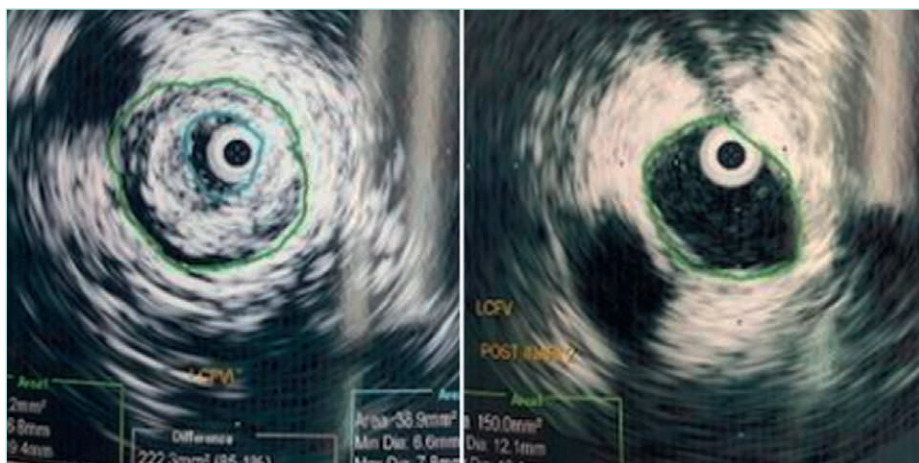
Peri-interventional intravascular ultrasound before and after thrombus removal at the level of the common femoral vein. Left panel (within the green circle): hyperechogenic, older age, clot. Right panel (within the green circle): a cleared vein without thrombus.
